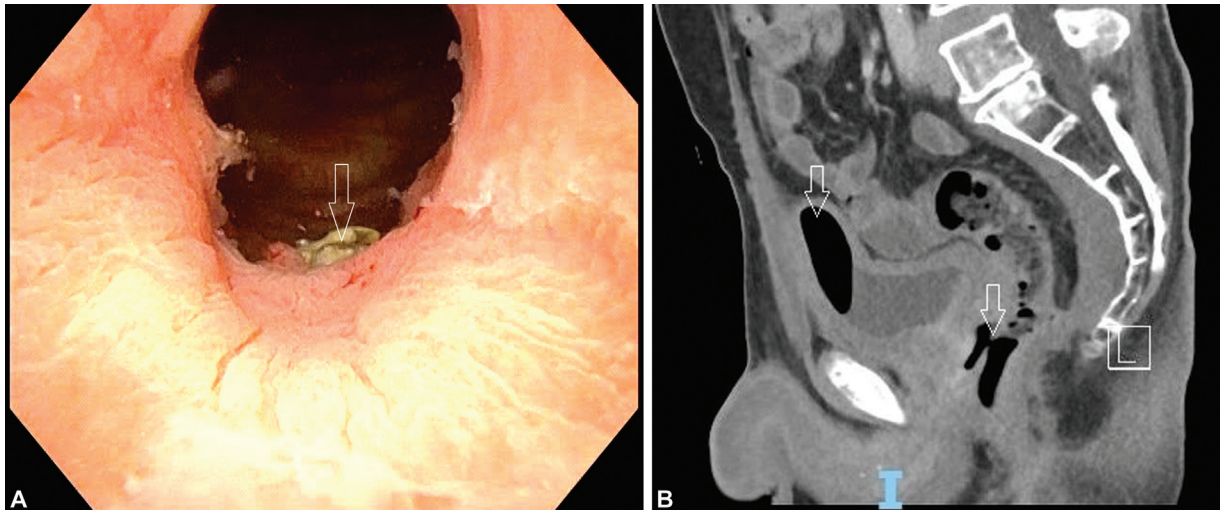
(A) Image of a Rectourethral fistula via cystoscopy (arrow points to the fistula). (B) CT image of a rectourethral fistula (left arrow points to air in the bladder and right arrow points to the fistula).
